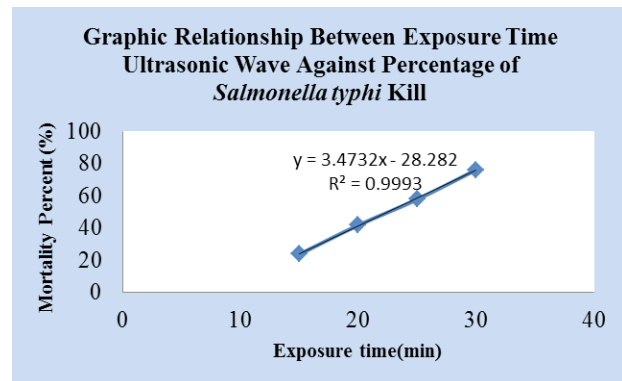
Graphic Relationship of Exposure Time Ultrasonic Wave against Percentage of *Salmonella typhi* Kill.
